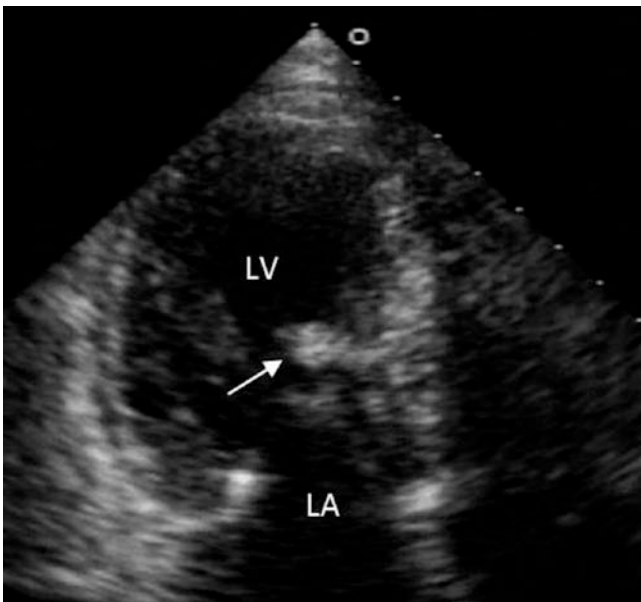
Apical 4-chamber view POC imaging of a hypertrophic cardiomyopathy with incidental finding of papillary fibroelastoma. It measures 3.5 cm in diameter; it is highly mobile and attaches to interventricular septum with a stalk. *LA* left atrium, *LV* left ventricle
